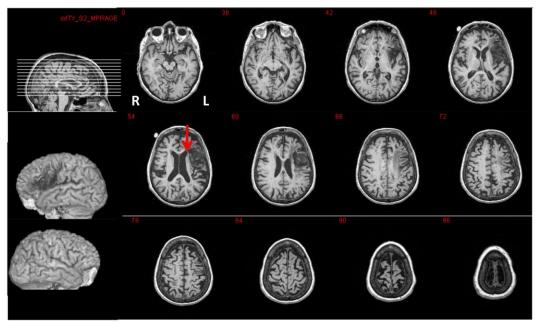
Structural T1-weighted MRI scan for participant ITY. Lesion present in cortex and subjacent white matter (WM) predominantly in left frontal lobe, including most of Broca's area, the insula, motor/sensory (mouth and hand), inf MFG, with extension into portions of the supramarginal and angular gyri, and planum temporal; lesion extended into the basal ganglia and was also noted in the medial scF (red arrow), one of two regions known to be compatible with severe nonfluent speech (Naeser et al., 1989). Some white matter lesion and lacunar infarcts along with general bilateral cortical atrophy associated with aging was noted.
